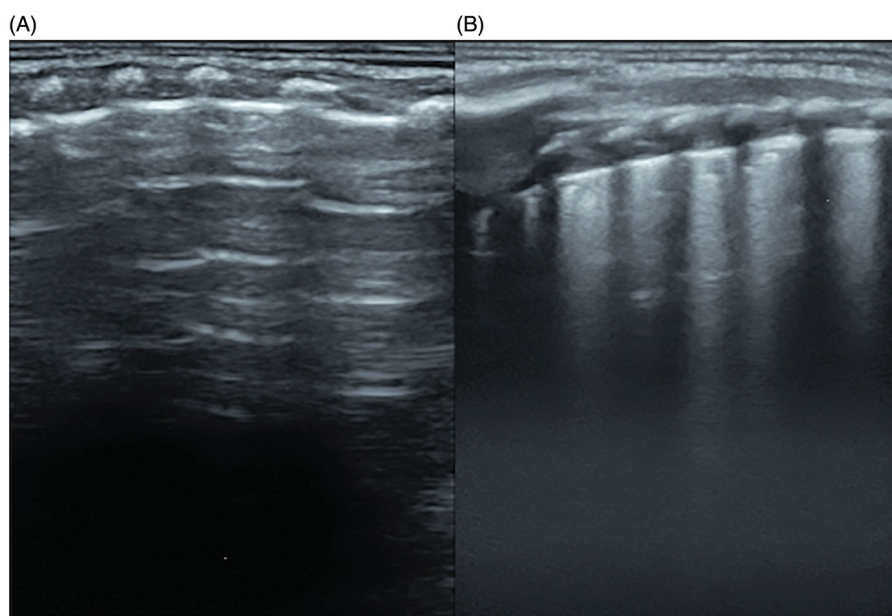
Impact of US transducer frequency on the LUS image quality. Different images from the same area in an infant with respiratory distress using different frequency transducers. (A) The image by linear transducer with a frequency below 9 MHz showed normal ultrasound findings. (B) The image by linear transducer with a frequency higher than 10 MHz showed subpleural lung consolidation and coalescent B-lines.
